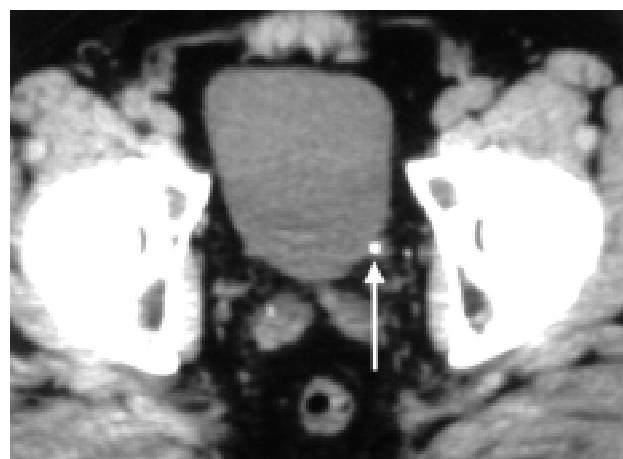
Non-contrast helical CT scan reveals a stone (arrow) in the distal left ureter, just proximal to the ureteral tunnel.trasound is that ultrasound is extremely operator-dependent. It is ideally performed by personnel experienced in uro-ultrasonography.
